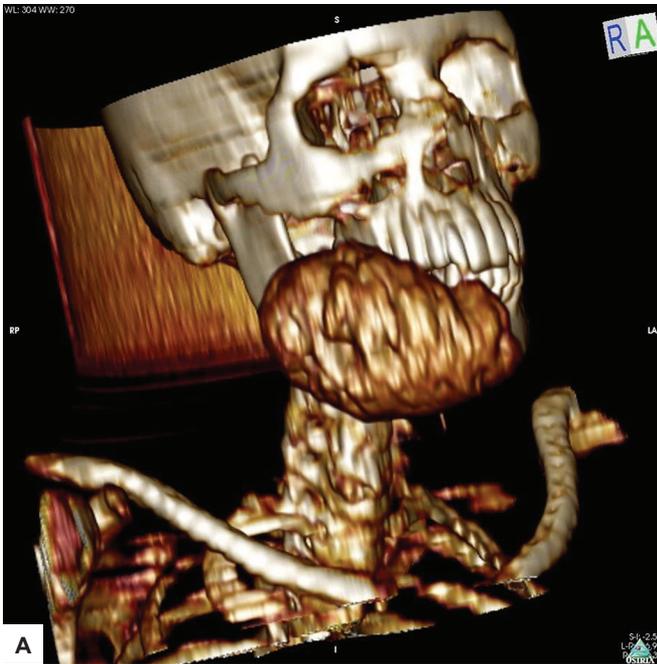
Computed tomography scan shows bone forming malignant mass arising from right hemimandible with sunburst periosteal reaction
